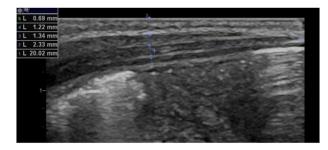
An example of the measurements performed on a saved deidentified ultrasound image of the abdominal wall musculature.
